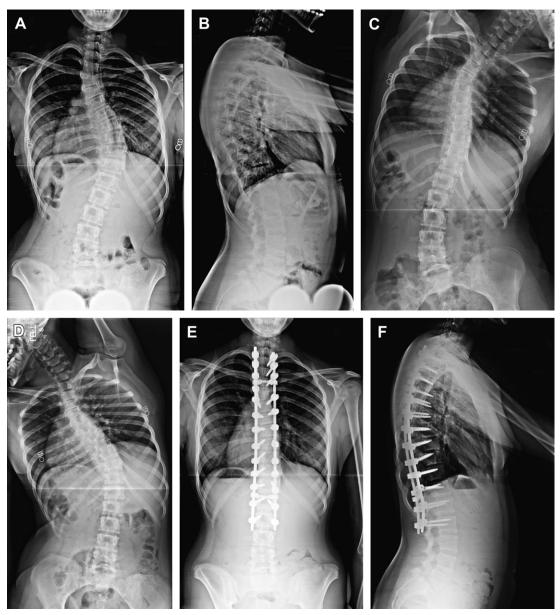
Lenke 2. Preoperative standing posteroanterior (PA) (A) and lateral (B) radiographs of a 12-year-old girl with a right 45° main thoracic curve and a left 38° proximal thoracic curve. Right (C) and left (D) bend films show that the main thoracic curve bends down to 30° and the proximal thoracic curve bends down to 27°. One-month follow-up PA (E) and lateral (F) radiographs show correction of the main thoracic curve to 16° and correction of the proximal thoracic curve to 17° with posterior pedicle screws from T2 to L2.
